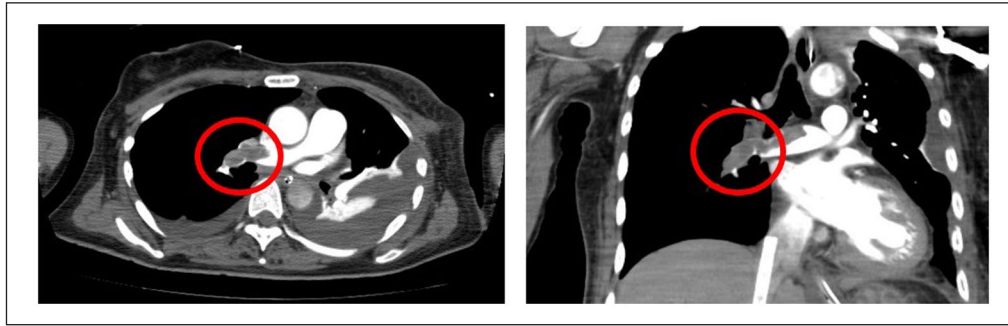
Contrast-enhanced computed tomography (CT) imaging findings. Contrast-enhanced CT images showed a thrombus in the right pulmonary artery (red circles).
